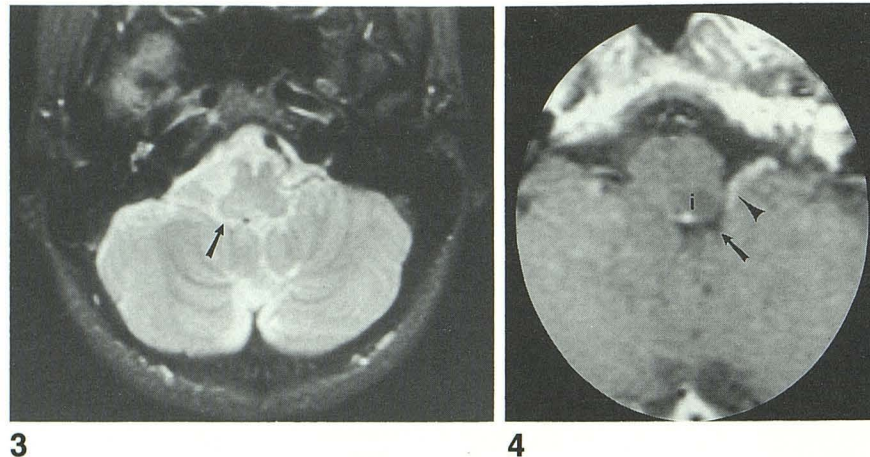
Axial MR image (1.5 T, 2500/90, 5-mm section thickness), patient three, subacute infarction. Signal aberration and slight swelling involving the right rostradorsal medulla along the foramen of Luschka, defined by the above landmarks as the region of the CNC. Arrow indicates CSF in the foramen of Luschka, outlining the CNC bulge. Autopsy 2 months after MR imaging showed infarction involving the CNC.
